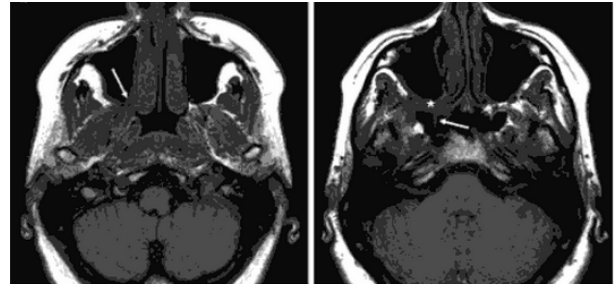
MRI of adenoid cystic carcinoma with extension to right pterygopalatine fossa.
